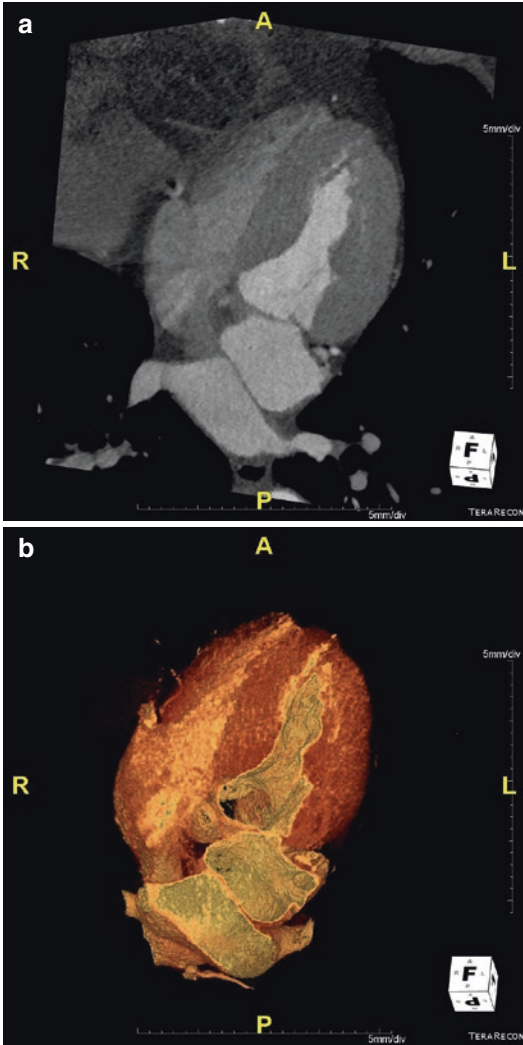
(a) Axial reconstruction of the gated CT showing cor triatriatum sinister with the usual configuration at the mid left atrial level. (b) 3D imaging of the same
